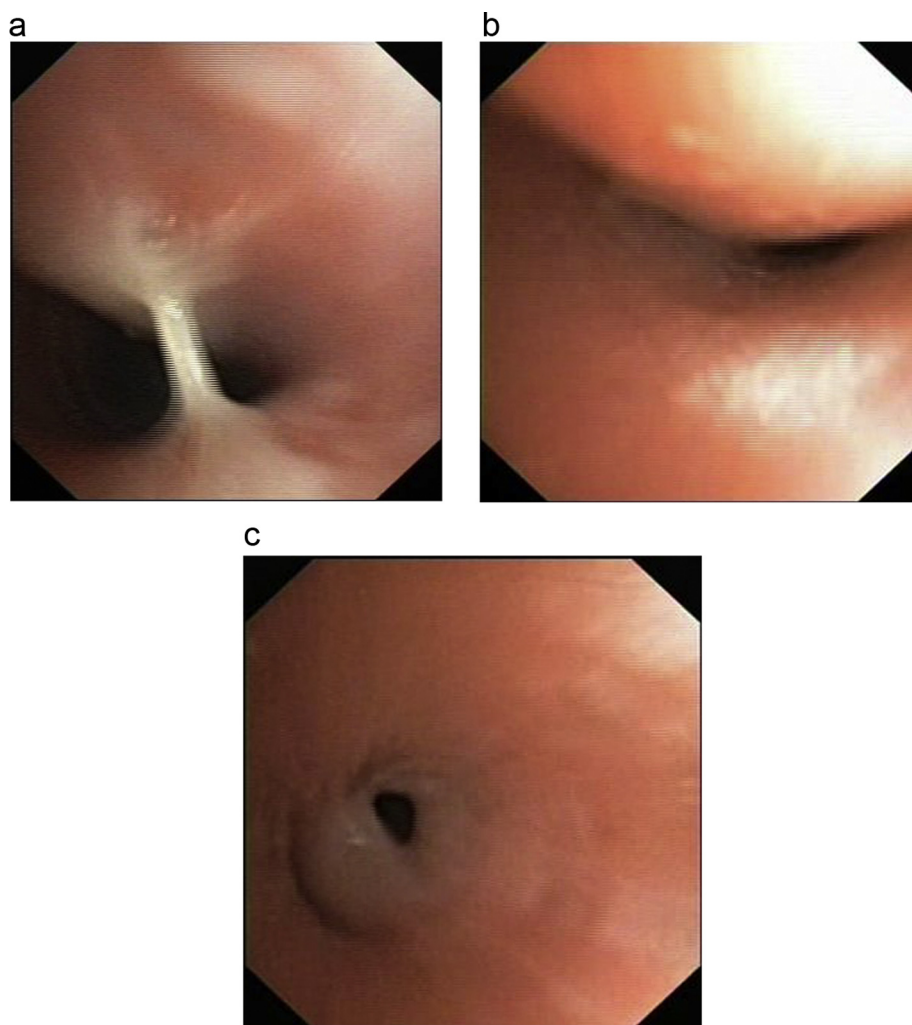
Profuse secretions and additional tracheomalacia both at inspiration (a) and expiration (b), and lingular bronchial stenosis (c) in a ten-year-old girl with chronic wet cough, recurrent pneumonia and cylindrical bronchiectasis at both lower lobe bronchi on chest CT scan.
